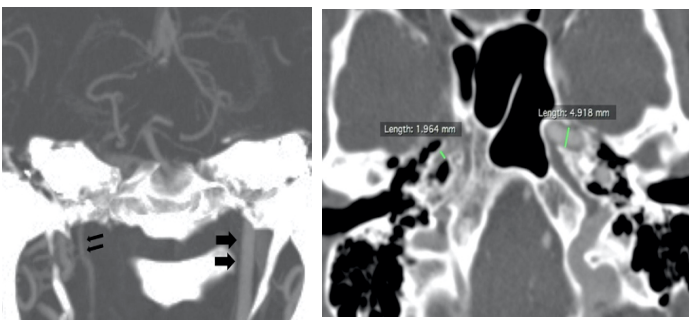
50-year-old man with internal cerebral artery (ICA) hypoplasia. Coronal maximum intensity projection CT image (a) shows right internal cerebral artery thinning (narrow arrows), the left is with normal calibration (wide arrows). On axial CT image (b), right carotid canal is small, supporting ICA hypoplasia.
